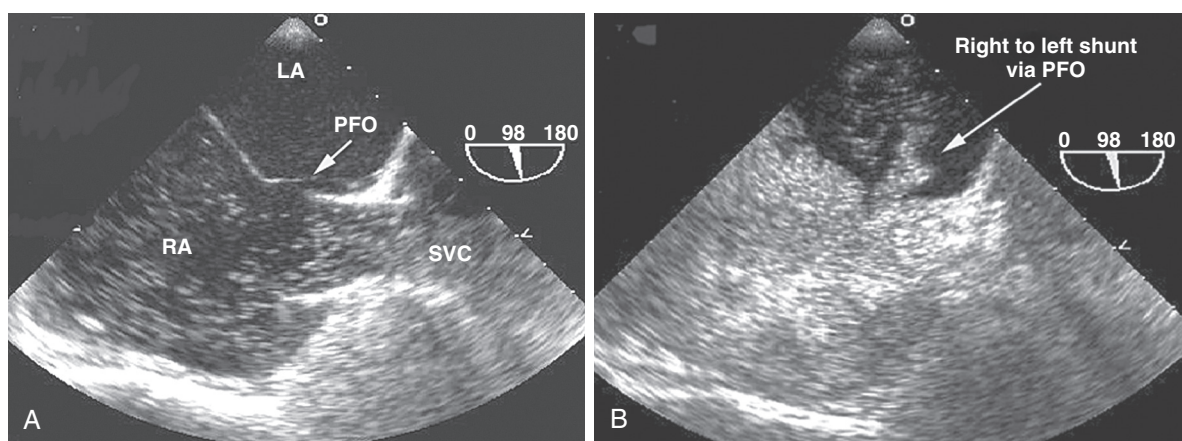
■ Positive bubble study shows the presence of a right-to-left shunt via a patent foramen ovale (PFO). Transesophageal echocardiography was performed in a patient hospitalized in the ICU for pneumonia. He presented with refractory hypoxemia that was out of proportion to the underlying minor pulmonary process. Transesophageal echocardiography was obtained (multiplane transducer at 98 degrees) and showed the presence of a patent foramen ovale with a significant right-to-left shunt due to elevated right atrial pressure. Soon after contrast injection (A), the bubbles are seen arriving in the right atrium (RA) from the superior vena cava (SVC). A few seconds later (B), a complete opacification of the right atrium is reached, and the bubble contrast is clearly seen shunting through the patent foramen ovale from the right atrium to left atrium (LA).
